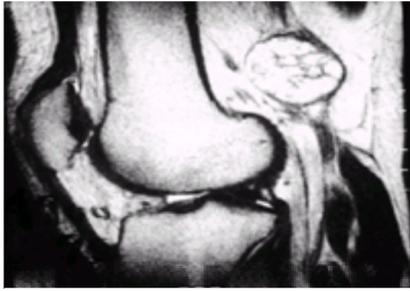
This is a sagittal view of a T1-weighted magnetic resonance image. The round, well-circumscribed mass posterior to the femur is within the peroneal nerve. It proved to be a schwannoma. Schwannomas have a typical appearance on magnetic resonance images. If they arise from a major nerve, as is the case in this patient, the nerve can usually be traced into the lesion. The schwannoma is smooth, slightly oblong, and has both bright and intermediate signals.
